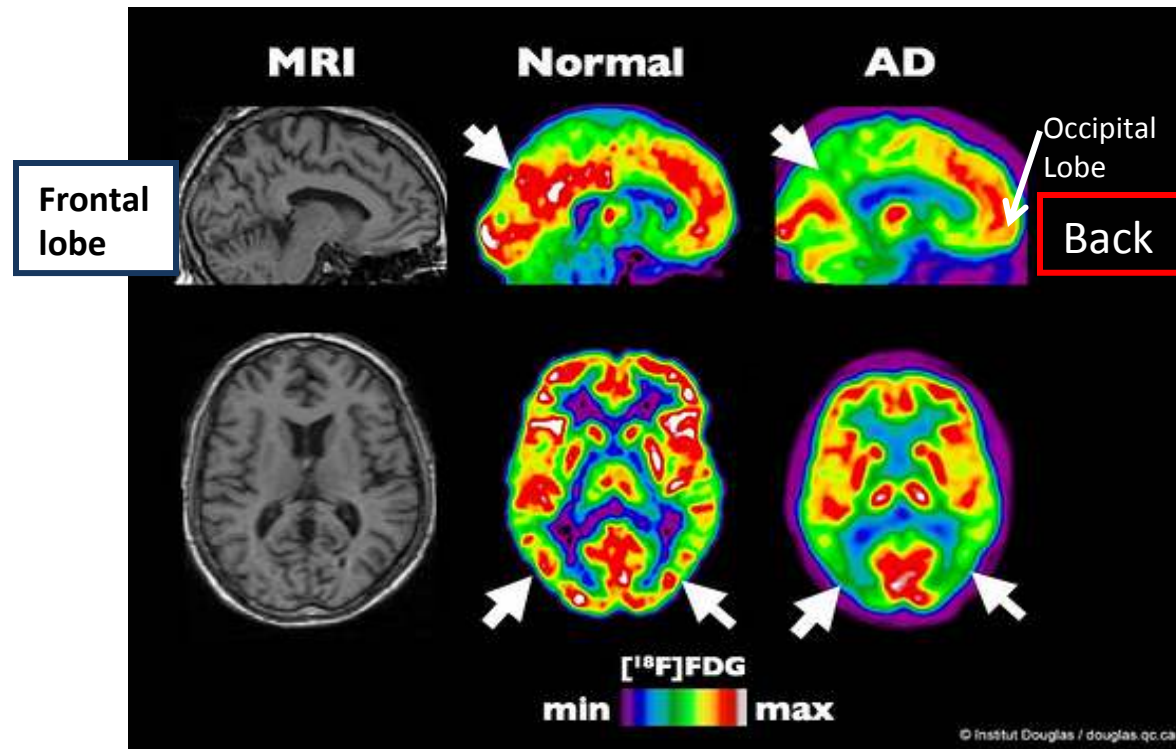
A. Left: PET Scan of a healthy human brain= SPECT/PET (single photon /positron emission computed tomography):
